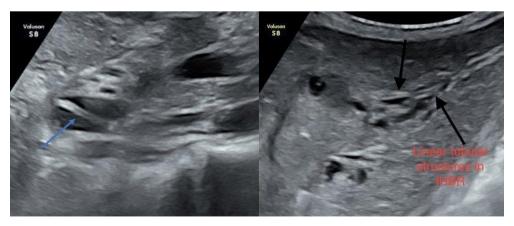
(A,B). Ultrasound shows dilated CBD and left hepatic duct with intraluminal tube like structure (Inner tube sign)
